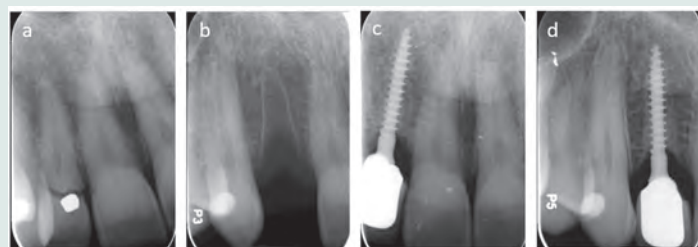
Preoperative radiographic analysis. 1a: Horizontal crown fracture of #7 was identified. 1b: Dental extraction was done. 1c & 1d: Three years later, patient appeared with narrow-diameter implant on previously extracted site.
